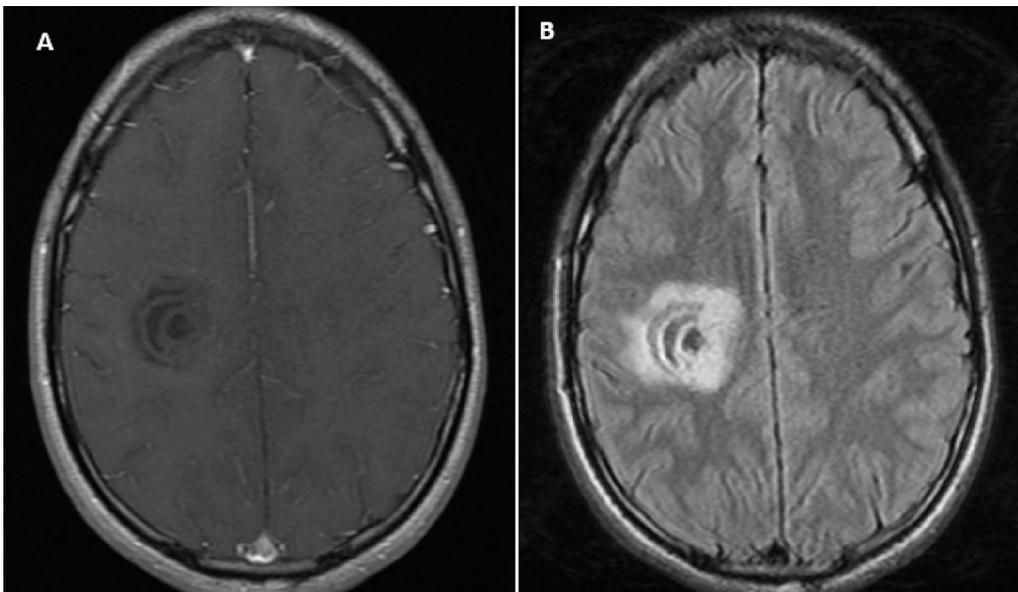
Magnetic resonance imaging two months after presentation with postcontrast T1 (A) and fluid-attenuated inversion recovery (B).
